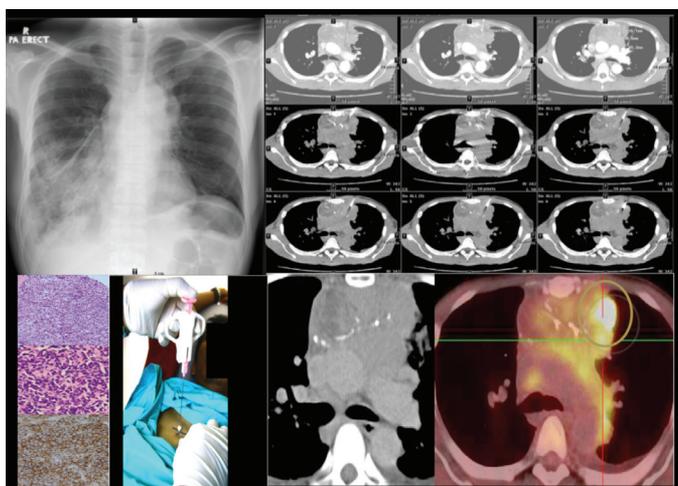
PET-CT guided biopsy: A new horizon in clinical utilization
